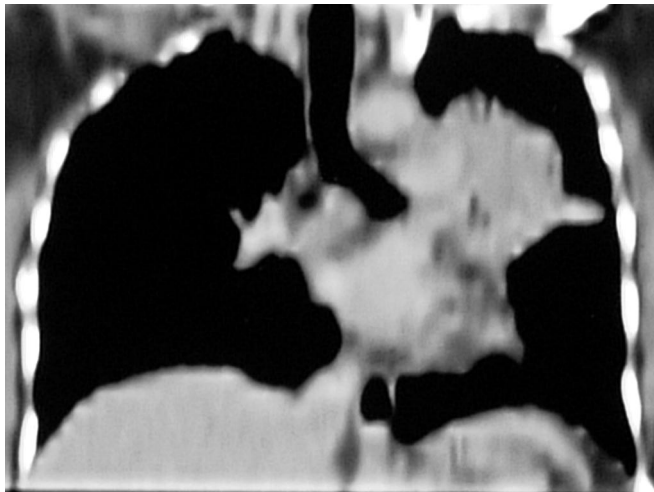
Pretreatment CT scans of thorax (coronal view).
